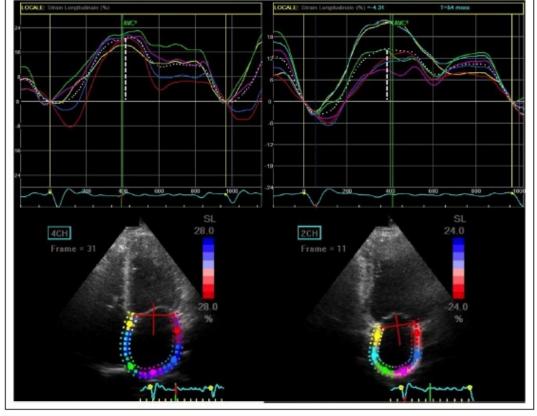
Measurement of peak atrial longitudinal strain (PALS) using speckle tracking echocardiography from apical 4-chamber (4CH; left) and 2-chamber (2CH; right) views in a representative patient with heart failure with reduced ejection fraction.
